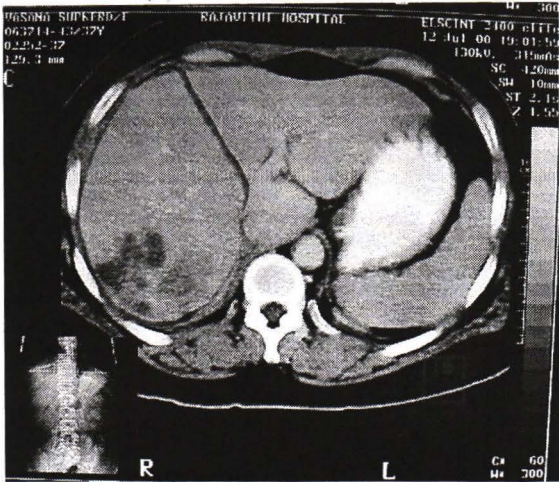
Marking the line of hepatectomy on the CT scan film.
